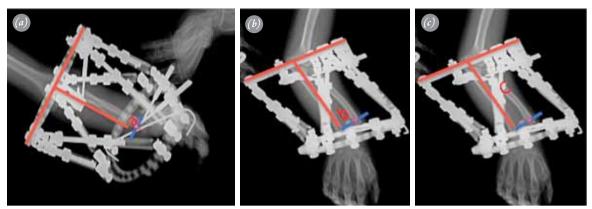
Measurements taken by digital radiography after surgery. The blue line indicates the osteotomy side and the red star in the middle of the blue line indicates the origin. (a) Lateral frame offset (a: the distance between the red line [middle of the reference ring] to the red star [origin]). (b) Anteroposterior frame offset (b: the distance between the red line to the red star). (c) Axial frame offset (c: the distance from the reference ring to the osteotomy side). [Color figures can be viewed in the online issue, which is available at www.aott.org.tr]
